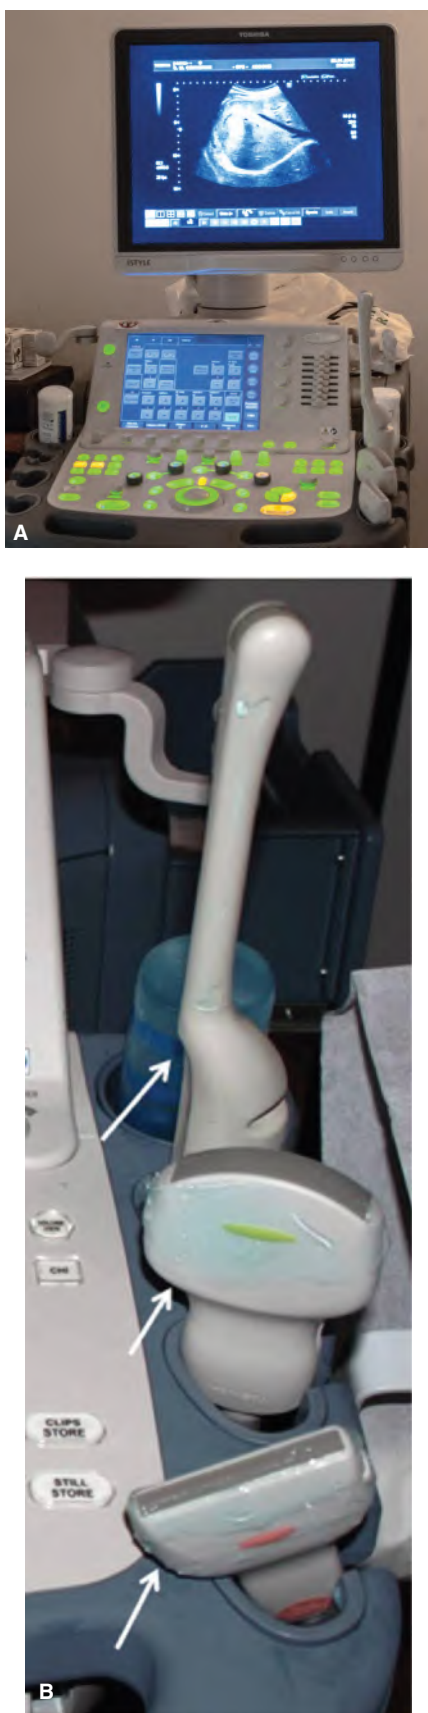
2 Ultrasound technical equipment. A. Ultrasound imaging apparatus with the transducers. B. Detail of three different transducers/probes (arrows).
